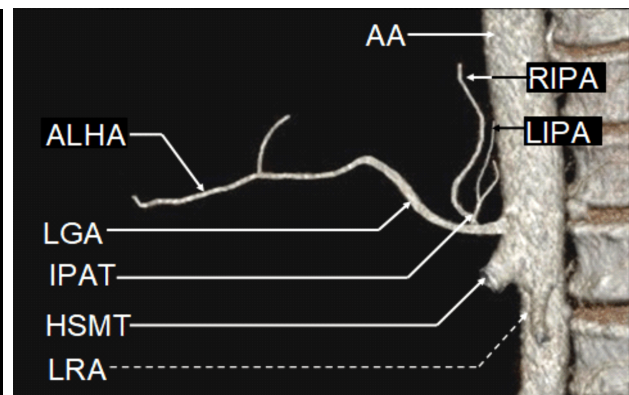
MDCT angiography of the AA. Rendered 3D images show the LGA with IPAT (with RIPA and LIPA) and ALHA: left aspect. MDCT: Multidetector computed tomography; AA: Abdominal part of aorta; 3D: Three-dimensional; LGA: Left gastric artery; IPAT: Inferior phrenic artery trunk; RIPA: Right inferior phrenic artery; LIPA: Left inferior phrenic artery; ALHA: Accessory left hepatic artery; HSMT: Hepato-spleno-mesenteric trunk; LRA: Left renal artery.
